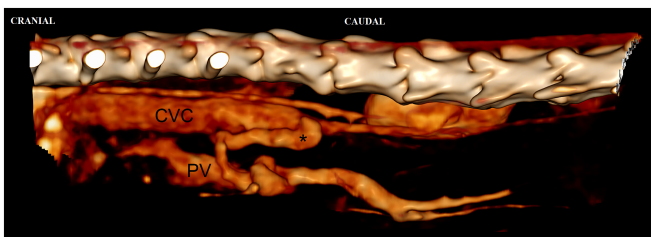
3D volume CT angiography re-constructed image of the vasculature, left-lateral view. The U-shaped aberrant vessel (*) can be seen curving from the ventrally positioned portal vein towards the caudal vena cava. PV Portal vein, CVC Caudal vena cava
